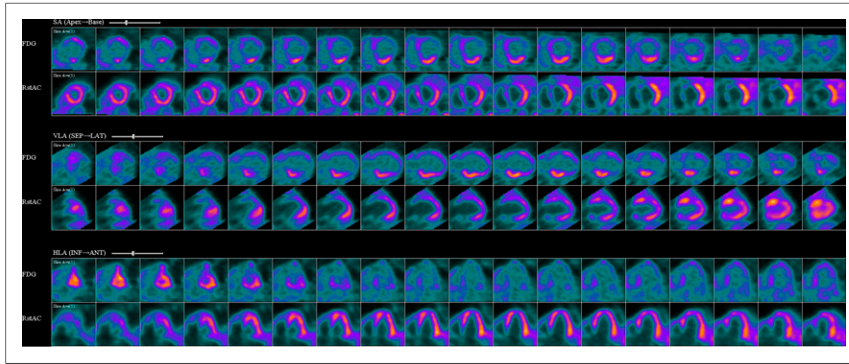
Perfusion images demonstrating defects in mid to basal inferior wall, basal anterior walls, and anteroseptal and inferoseptal areas, as indicated by correspondingly increased ^{18}F -FDG uptake in these regions.
